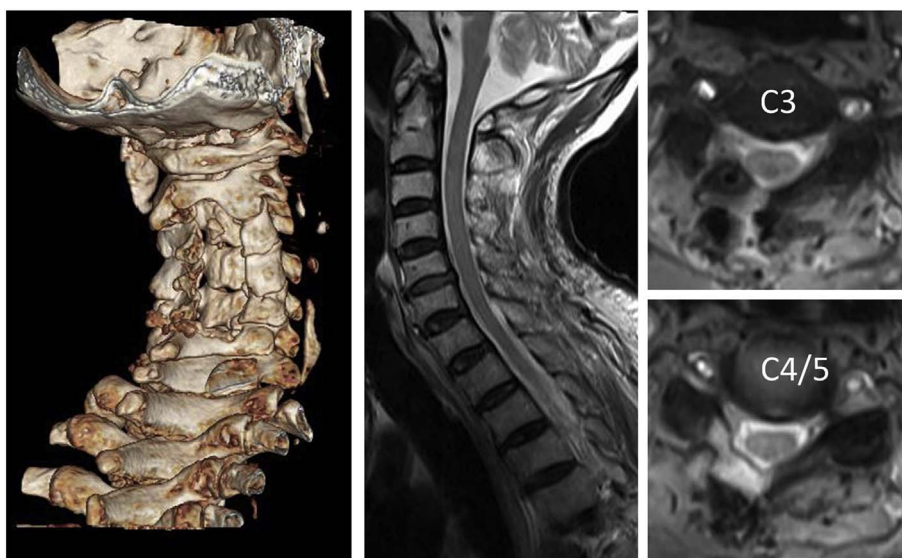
Left: Three dimensional reconstructed image of cervical bone CT. Middle: MRI sagittal view on T2weighted image. Right: MRI axial views on T2weighted images. Post-operative CT showed hemilaminectomy over the right side from C2 to C7 (left). Post-operative MRI demonstrated total removal of epidural hematoma and good decompression over the surgical area(middle and right).
